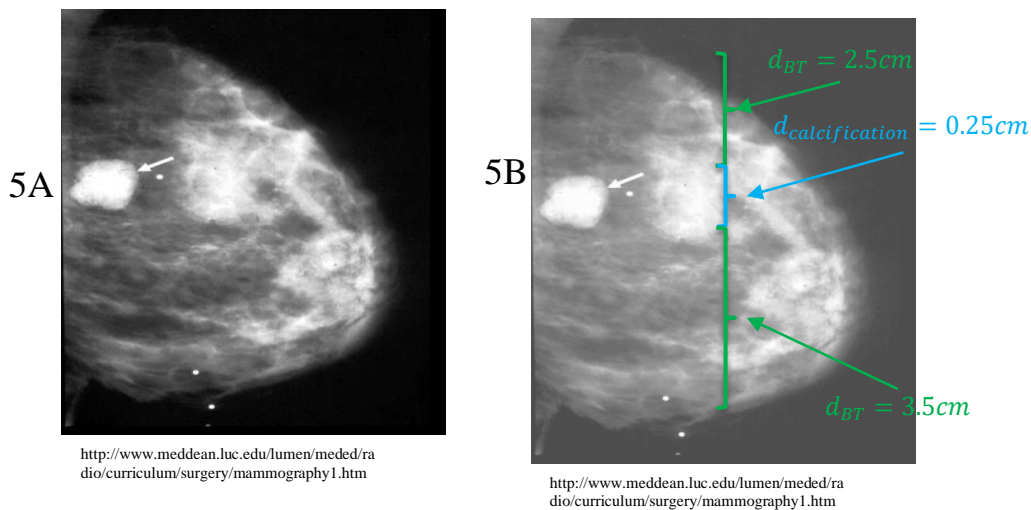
X-ray image of (Figure 5A) and labeled image of (Figure 5B) a female breast.
